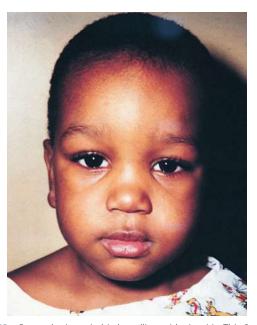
Sympathetic periorbital swelling with sinusitis. This 2-year-old boy was seen late in the afternoon with fever, wet cough, decreased activity, and mild infraorbital puffiness. The swelling was neither red, indurated, nor tender and reportedly had been more marked on awakening in the morning. He also had a scant cloudy nasal discharge. His chest radiograph was normal, but sinus films showed opacification of the maxillary sinuses.
